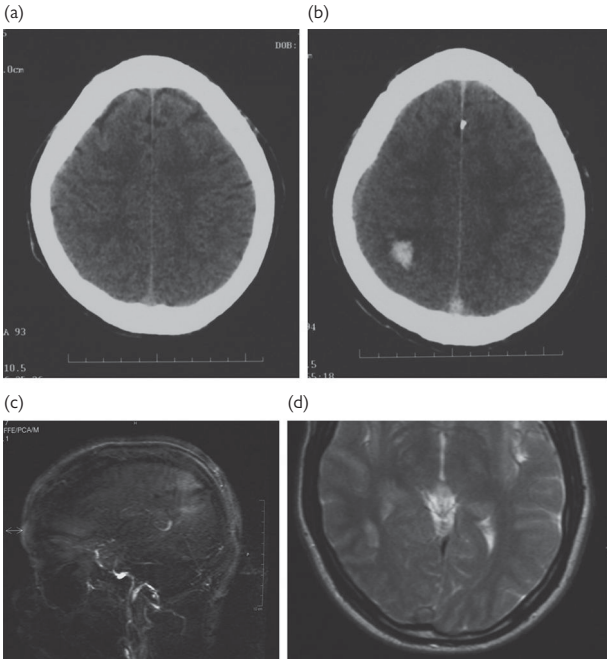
This patient presented to the acute stroke unit with headache, nausea, and vomiting. (a) The initial CT showed no haemorrhage but a 'delta sign' was present, indicating thrombus in the posterior part of the superior sagittal sinus. (b) On CT scan at day 5, haemorrhage can now be seen in the right parietal lobe. (c) MRA confirmed the diagnosis, showing absence of flow in the superior sagittal sinus. (d) On MRI, a thrombus within the sagittal sinus can be seen. © Hugh Markus.
